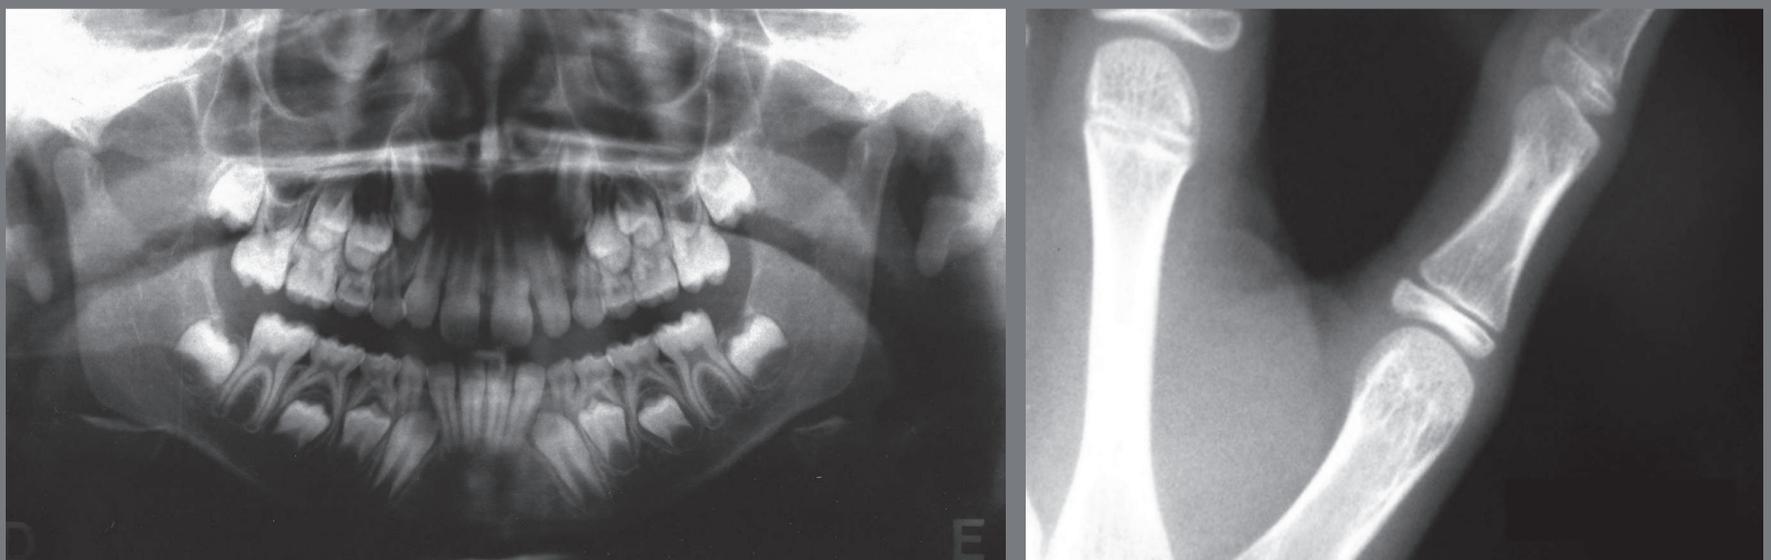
Initial panoramic and hand-wrist radiographs.
